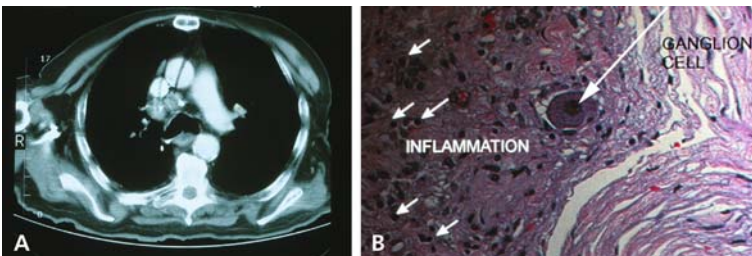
Paraneoplastic ganglionopathy in a patient with a non-small cell carcinoma of the lung. A CT chest showing enlargement of the mediastinal lymph nodes. B Single dorsal root ganglion (DRG) neuron (large arrow) and evidence of inflammatory cell infiltrates (white arrows). Most of the DRG have degenerated
